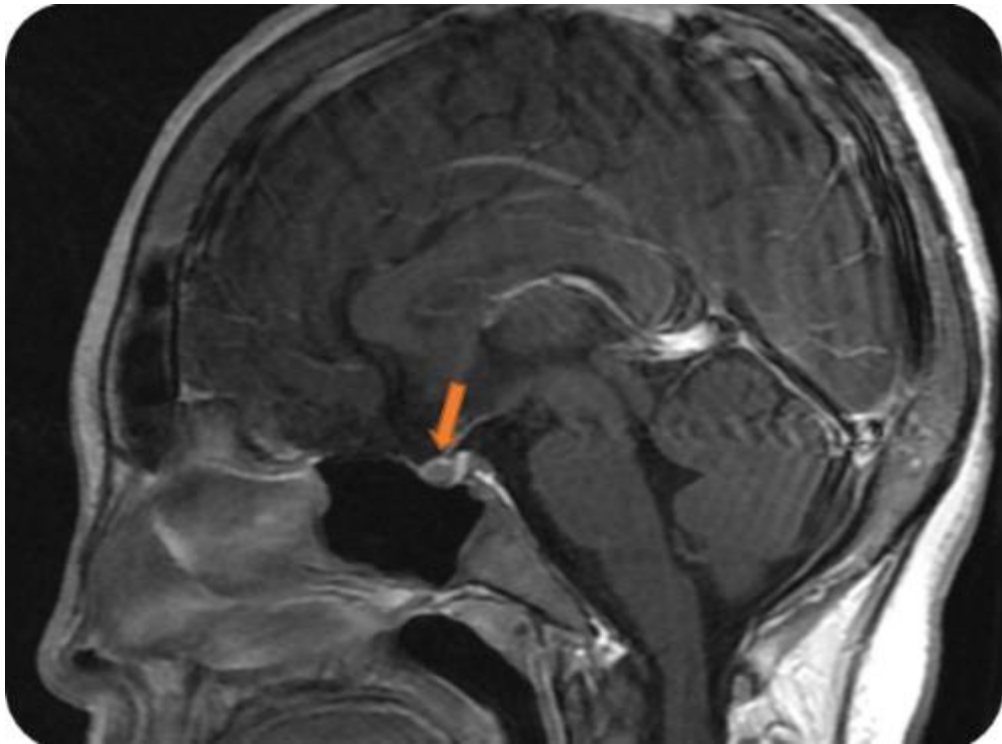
Gadolinium-enhanced T1-weighted sagittal section: Age-appropriate pituitary gland size, with no structural abnormality (Orange arrow)
